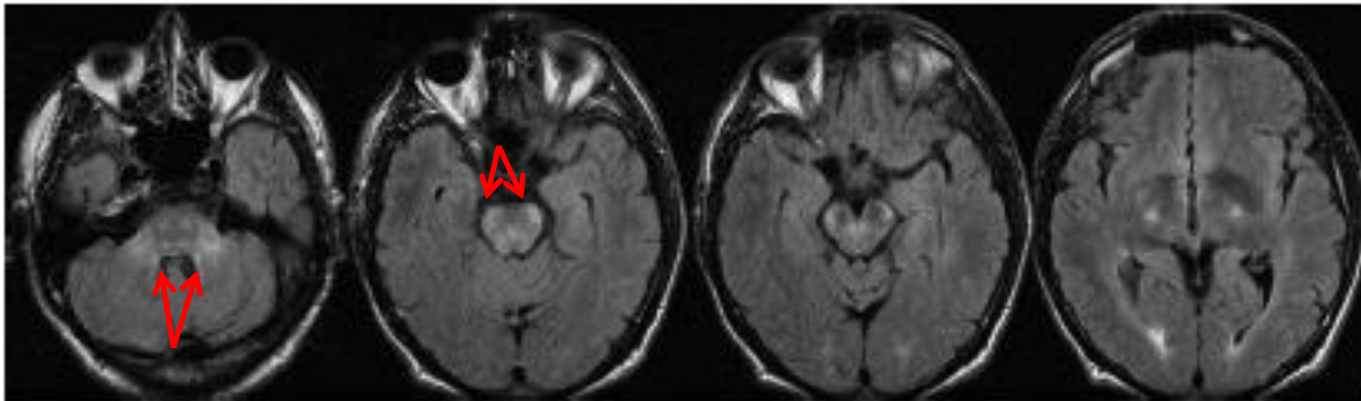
Axial noncontrast FLAIR MRI images demonstrate bilaterally symmetric T2 signal-intensity abnormality without mass effect, involving the corticospinal tracts, brain stem, and brachium pontis.
